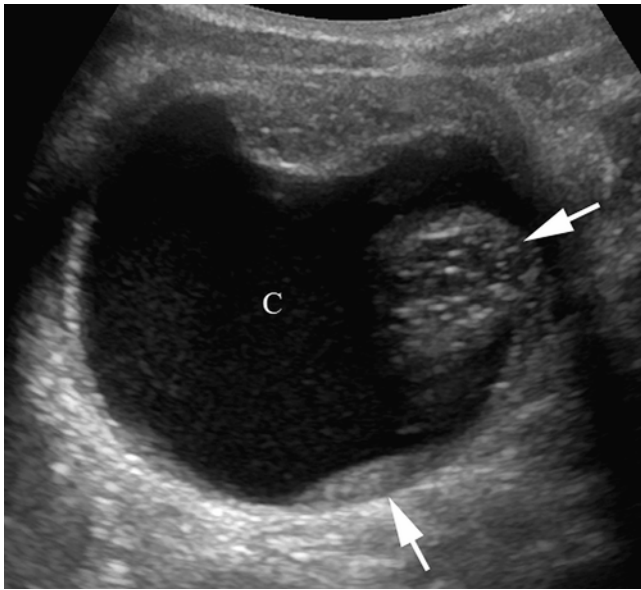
This transverse ultrasound (US) image of an ovarian teratoma reveals the cystic (C) and solid (*arrows*) components that are typical of this tumor
